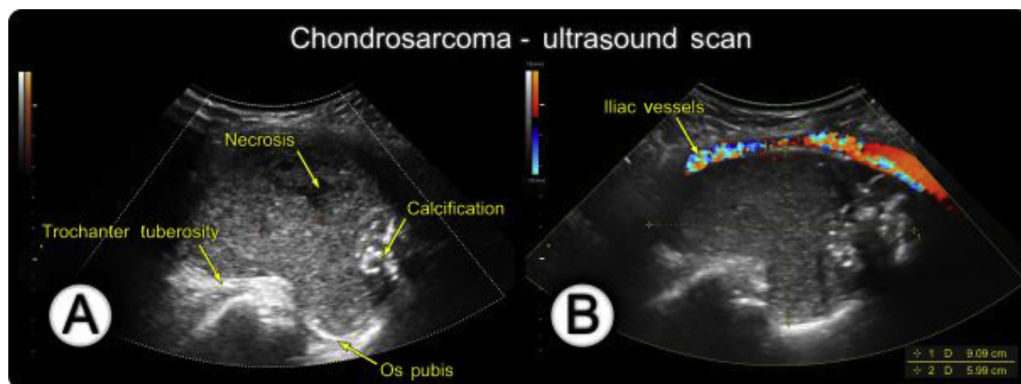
Ultrasound scan of chondrosarcoma. (A) A hypoechoic solid tumor with mild vascularity, hypoechoic necrotic portion and calcification; (B) the external iliac vessels bulged by the tumor on color Doppler.
